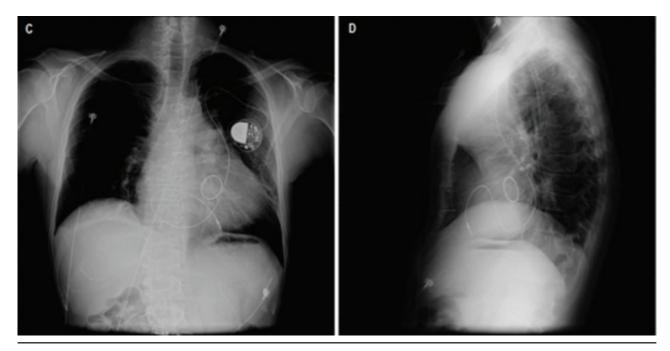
Chest X-ray (Posteroanterior View, C and lateral view, D) Showing the Final Lead Location in the Right Ventricle
